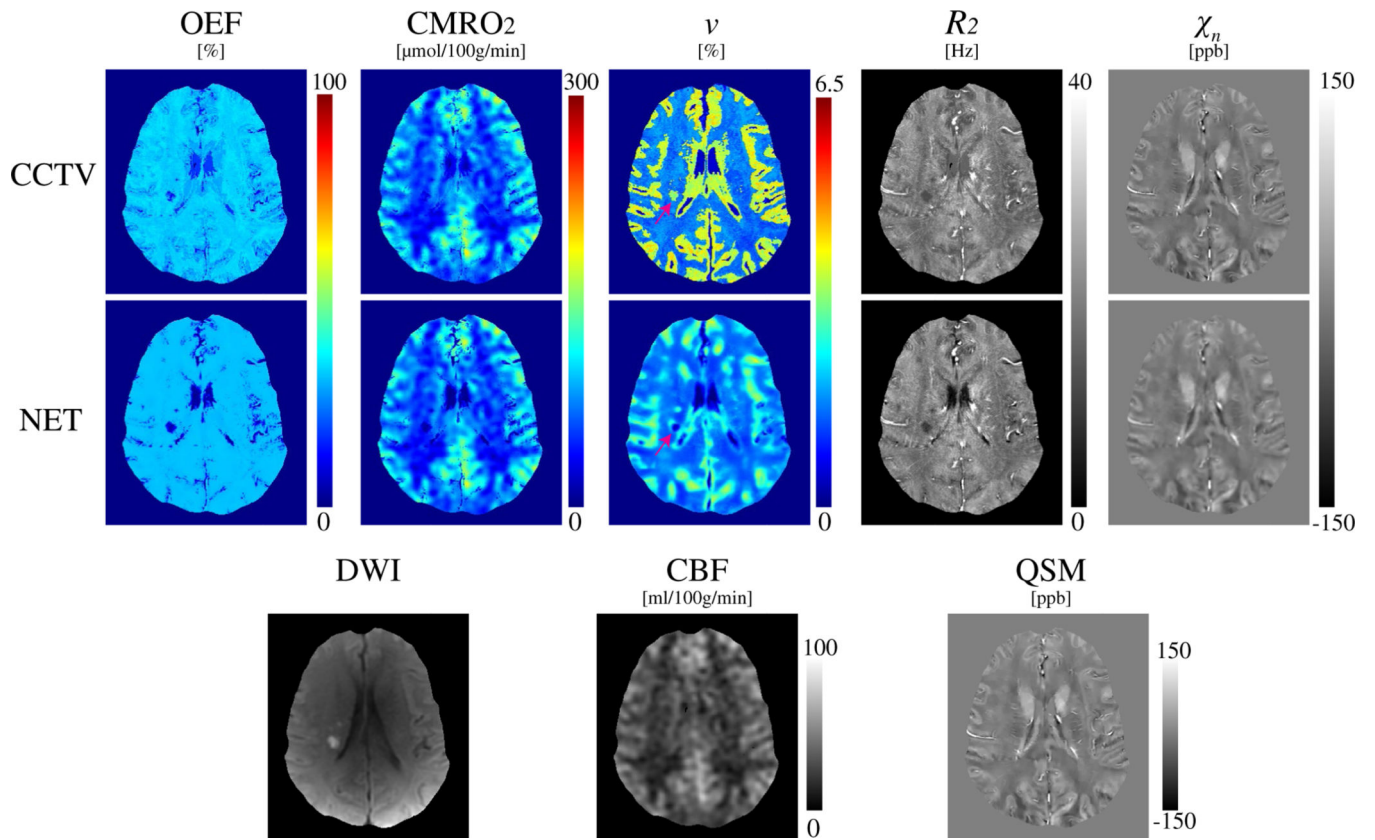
Comparison of OEF, CMRO₂, *v*, *R*₂, and χ_n maps between CCTV and NET in a stroke patient imaged 7 days post stroke onset (Test Data 2). NET provides less noisy OEF and low *v* values in DWI-defined lesions
